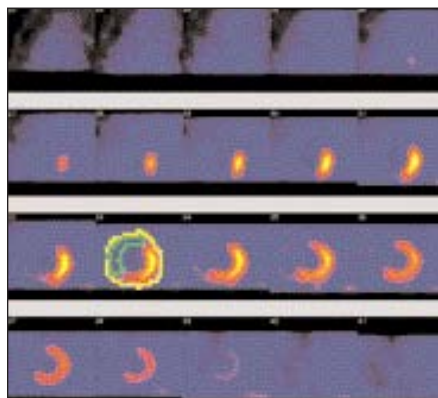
The ^{99m}Tc-MIBI SPECT rest cardiac pictogram images with the infarction size and the left ventricle drawn as the regions of interest (Courtesy of Universitas Hospital).
